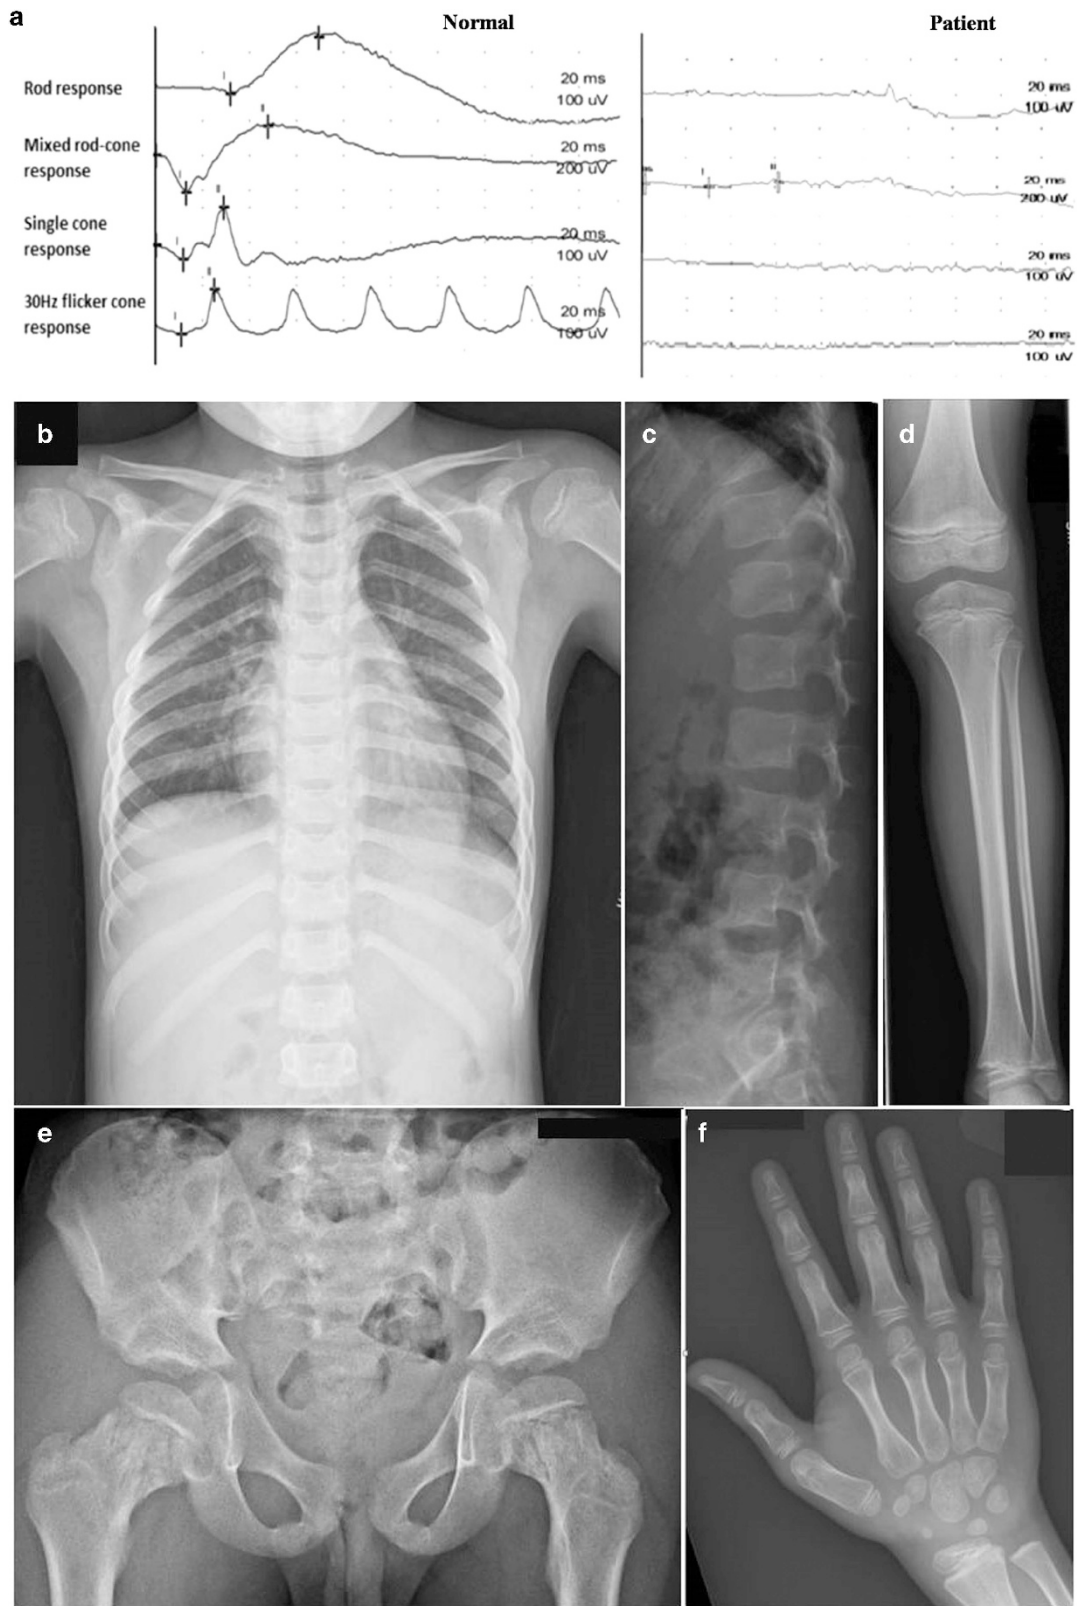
Clinical features of the patient. (a) Electroretinogram of the patient at age 11 years. Rod response, mixed rod-cone response, single cone response and 30 Hz flicker cone response of a normal subject (left) and the patient (right). The patient showed extremely diminished mixed rod-cone response with non-recordable rod response, oscillatory potentials and cone responses, indicating a widespread retinal degeneration. (b–f) Radiographs of the patient at age 8 years. (b) Chest A-P. Narrow thorax with short ribs. (c) Lateral spine. Mild platyspondyly with rounded, dorsally wedged vertebral bodies. (d) Lower leg A-P. Mild metaphyseal broadening of the proximal tibia. (e) Hip A-P. Short ilia with narrow greater sciatic notches and horizontal acetabula, mildly flat capital femoral epiphyses, and irregular trabeculae in both femoral necks. (f) Hand A-P. Mild shortening of the 4th and 5th metacarpals.
